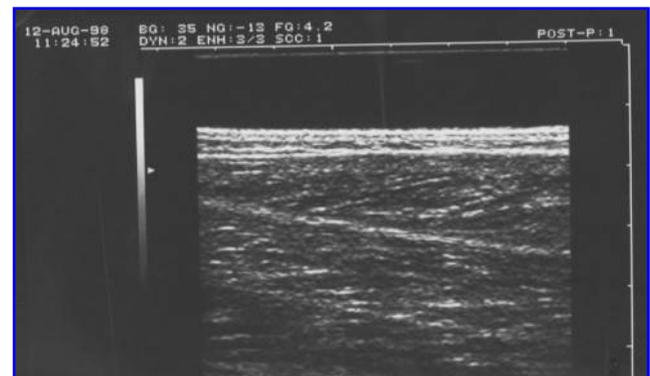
Sonography findings on day 12 after successful therapy.
